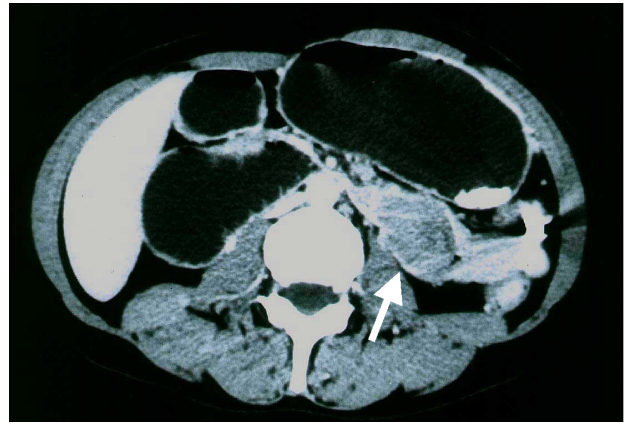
Abdominal enhanced CT scan showed a tumor (white allow) in left side of the abdominal aorta 6cm in size, and it showed an expanded stomach and duodenum..
